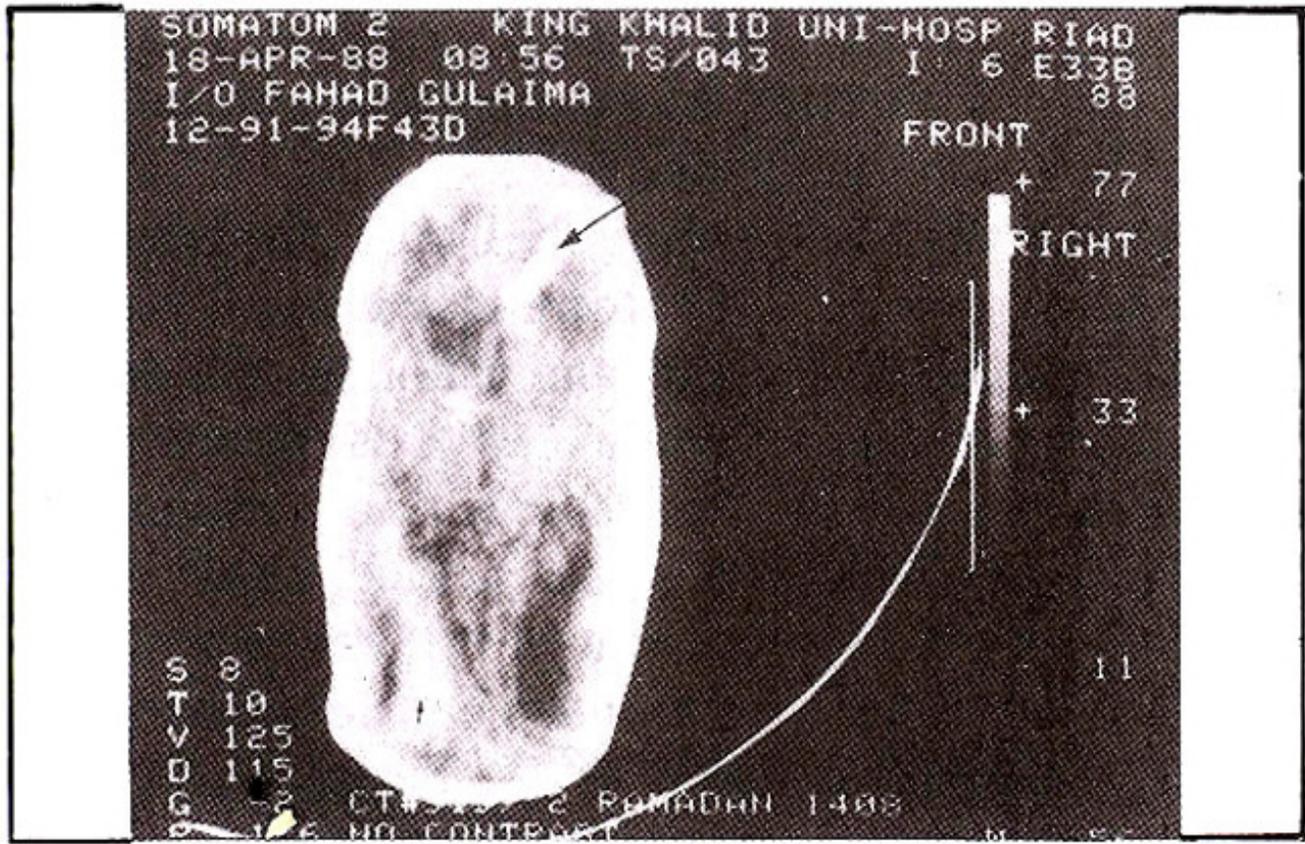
Post-EVD CT scan of the same infant showing complete resolution of PHH. Note (i) external ventricular drain through right frontal burr hole (arrow); (ii) normal ventricular size; (iii) intraparenchymal haemorrhage left occipital region (arrow).
